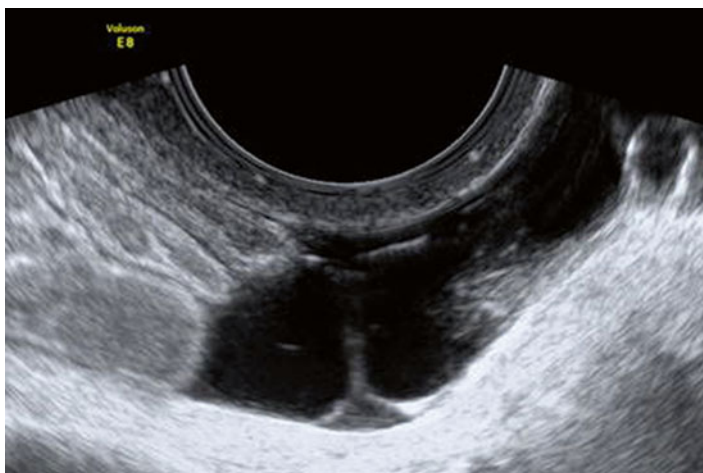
Peritoneal inclusion cyst by transvaginal ultrasound (Reprinted from Coccia et al. [74], Figure 6, with kind permission from Springer Science and Business Media)
